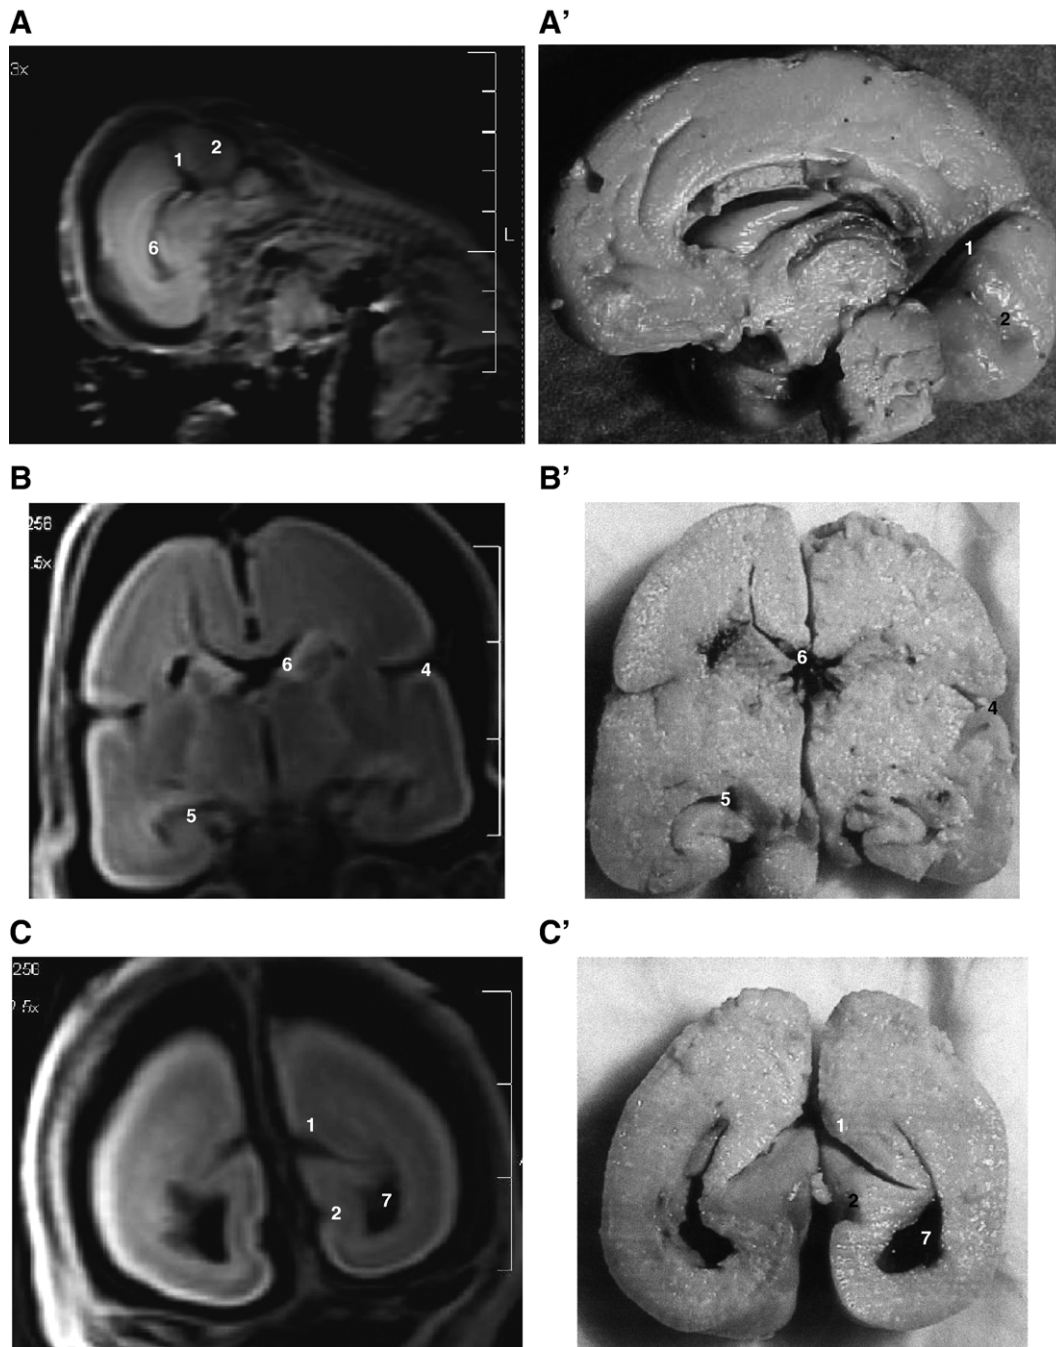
Magnetic resonance images and anatomical preparations from fetus number 5, post-conceptual age: about 23–25 weeks. A and A': Sagittal slice, B and B': coronal geniculocapsular slice, C and C': coronal parietooccipital slice. 1: Parietooccipital fissure, 2: calcarine fissure, 3: cingulate sulcus, 4: sylvian fissure, 5: hippocampic fissure, 6: lateral ventricle, frontal horn, 7: lateral ventricle, occipital horn.
